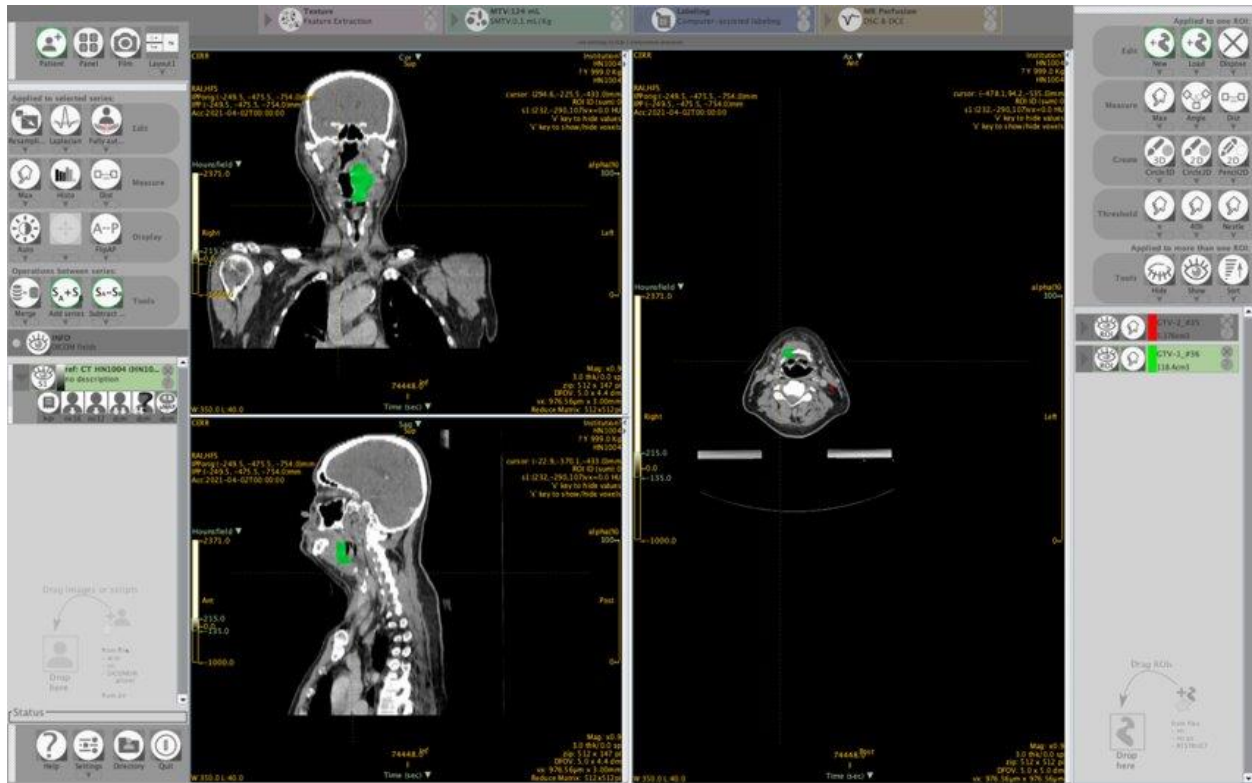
Head and neck cancer patient CT image in LifeX software
